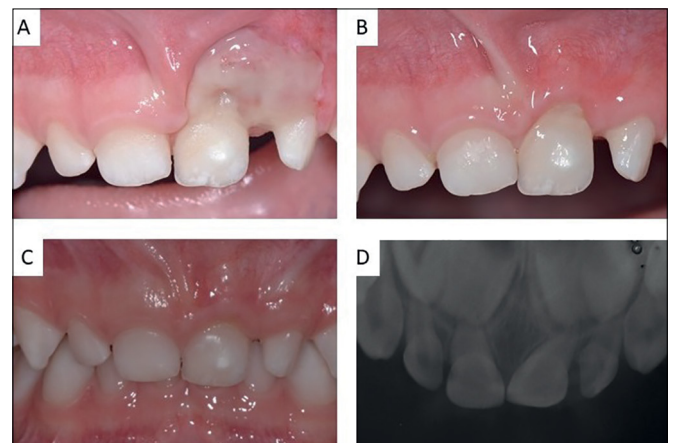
Clinical and radiographic follow up. (A) Clinical aspects after 15 days of surgical procedure exhibiting ulcerative area. (B) Clinical aspect after 60 days showing a small gingival defect. (C) After 180 days, an evaluation showed excellent healing of the oral mucosa. (D) Periapical radiograph after 180 days showing an absence of bone lesions.
